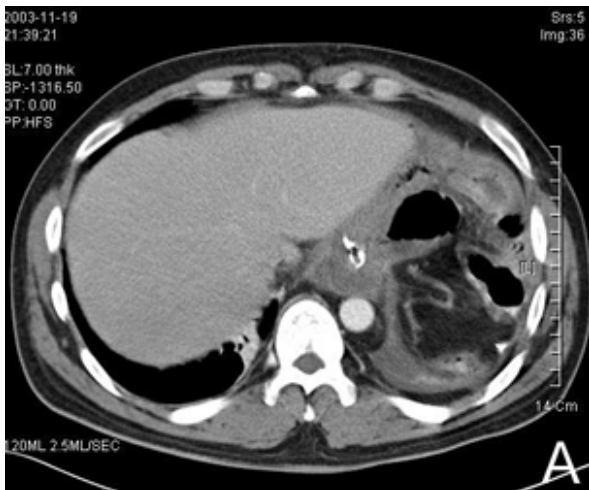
CT scan on the level of esophagojejunal anastomosis site shows fluid collection around the anastomotic suture material and in the left pleural cavity.
